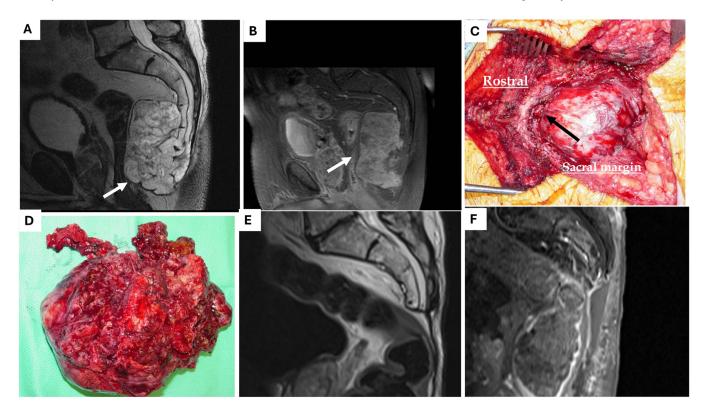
Large sacral chordoma in a 78 y.o. male patient that presented with a 3-year history of intermittent sacral pain, worse with prolonged sitting. MRI Pelvis was obtained with sagittal T2 (A) and T1 post-gadolinium (B) sequences showing a 9.8 cm X 5.8 cm lobulated, T2 hyperintense lesion with heterogeneous enhancement arising from the ventral coccygeal region. Patient underwent CT-guided excisional biopsy which confirmed a diagnosis of chondroid chordoma. He later underwent an en bloc resection of the mass with sacrectectomy (C) with the tumor appearing as a gelatinous, lobulated mass with regions of necrosis and hemorrhage along with nodes of calcifications (D). Follow up post op MRI pelvis with sagittal T2 (E) and post-T1 gadolinium sequences showing GTR of the mass with post-operative changes and no evidence of residual disease or CSF leak.
